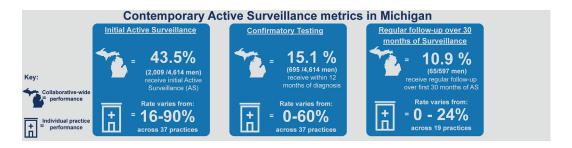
Contemporary active surveillance metrics in Michigan. Metrics reported for all eligible men diagnosed with favorable risk prostate cancer in MUSIC registry between January 2012 and October 2015. Practices were included in practice level variation reports only when 10 or more eligible men with sufficient followup were managed at that practice site. Confirmatory testing defined as receipt of either repeat prostate biopsy or multiparametric prostate MRI within 12 months of diagnosis, rates do not account for whether genomic test was used to confirm cancer risk. Regular followup defined as receipt of at least 4 repeat PSA tests and 2 tumor burden re-assessments (ie either prostate biopsy or prostate MRI) within 30 months of diagnosis.
